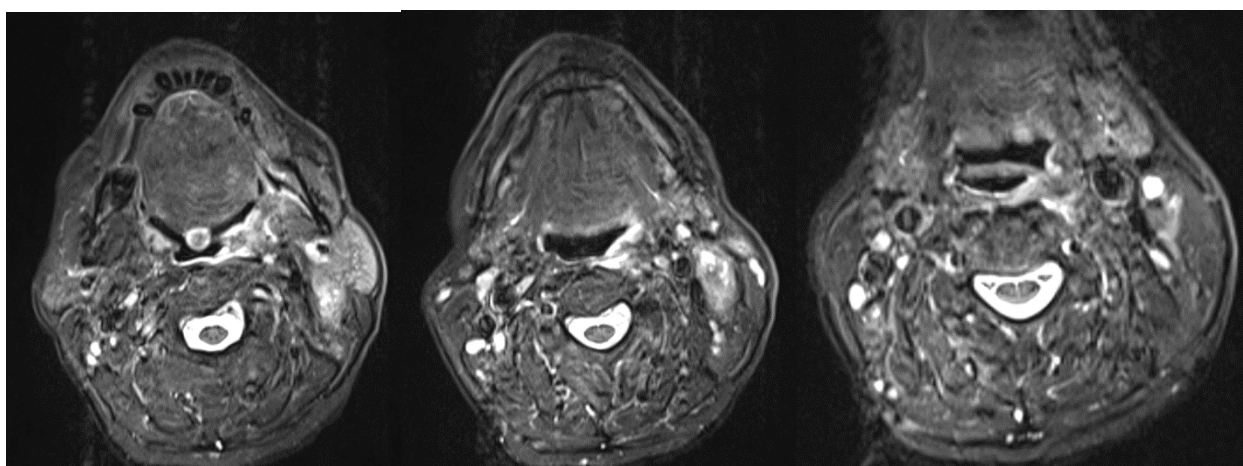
Post-chemotherapy CT coronal sections. a) CT image with coronal cut on the dorsal plane of the tongue; b) CT image with coronal cut in the mandibular plane; c) CT image with coronal cut in the plane of the hyoid bone.*
